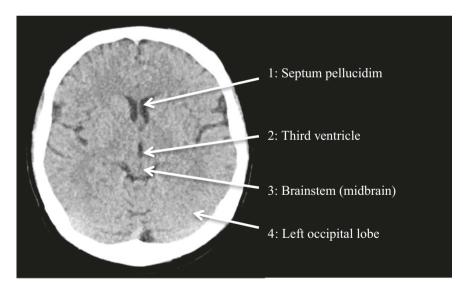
Axial non-contrast CT brain
